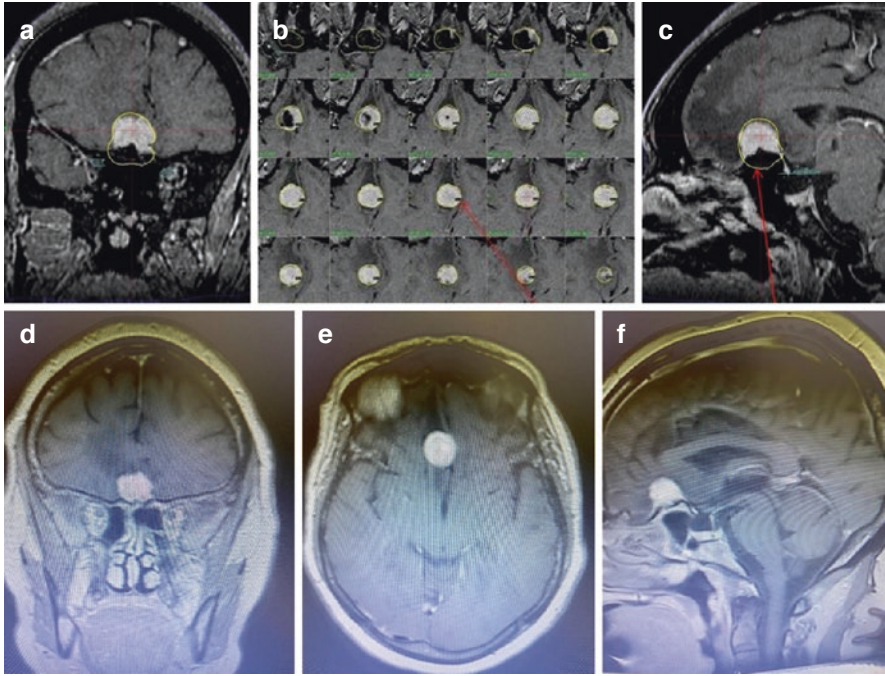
This is a 60-year-old woman found incidentally to have a planum sphenoidale meningioma with a calcified base and some edema. The patient was treated with Gamma Knife (a: postcontrast T1 coronal MRI image at the time of Gamma Knife treatment; b: postcontrast T1 axial MRI images at the time of Gamma Knife treatment; c: postcontrast sagittal MRI images at the time of Gamma Knife treatment). Four years later, the patient had no symptoms, and the tumor remained stable (d: postcontrast T1 coronal MRI image; e: postcontrast T1 axial MRI image; f: postcontrast T1 sagittal MRI image)
